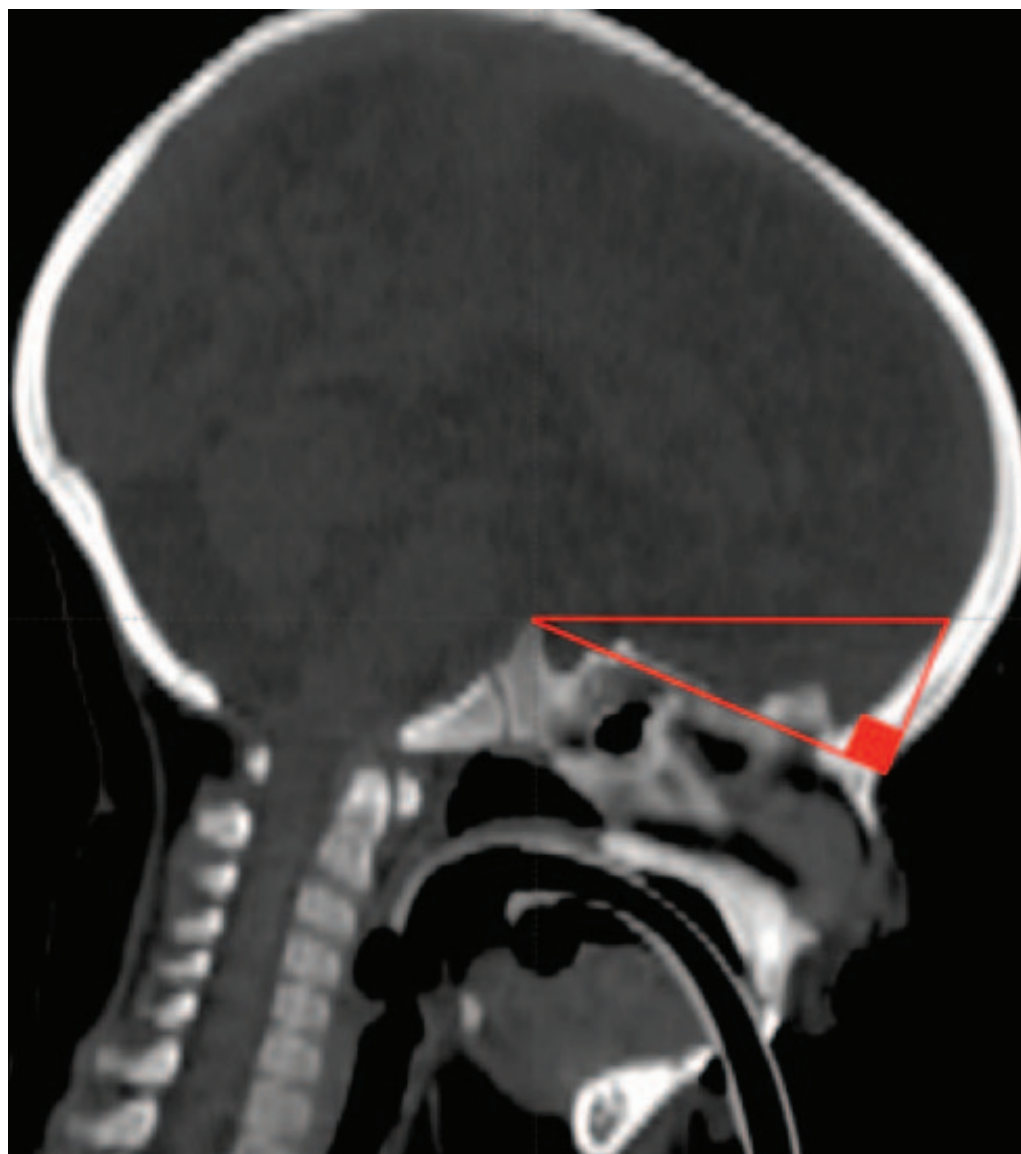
Correction of temporofrontal angle for head position. Sagittal head computed tomography (CT) scan at the midline was used to measure the positions of the nasion and the posterior clinoid process. Those coordinates were then used to determine the relative degree of flexion versus extension of the head. A cosine of that angle was applied to the measured hypotenuse to compensate for overestimation of that component on CT scan measurements.
